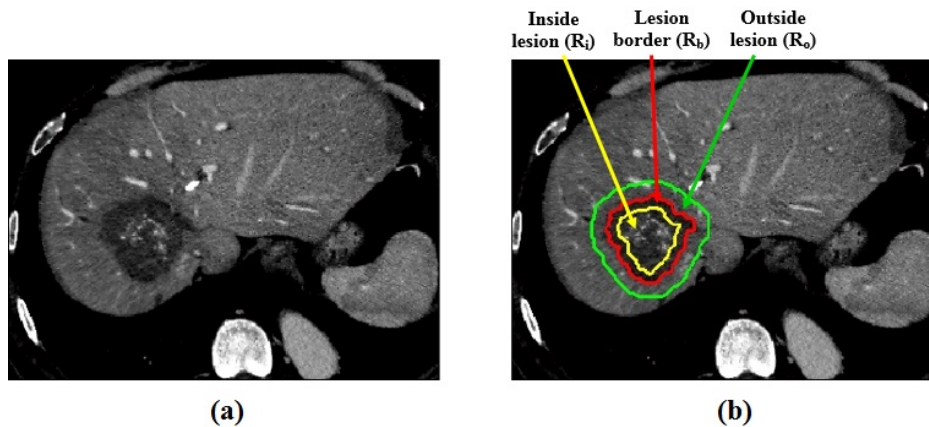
Divided lesion into Multiple ROIs; (a) Original CT image; (b) Multiple ROIs (inside lesion, lesion border and outside lesion).
